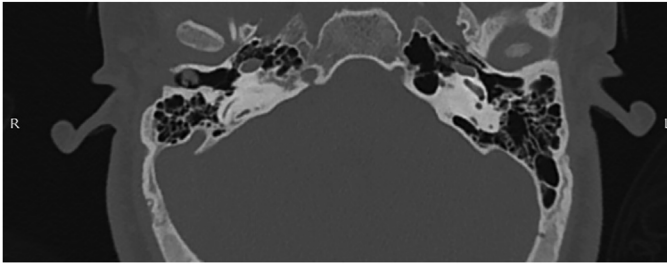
Axial CT scan showing ASEEC Right ear with cerumen (*white arrow*) plug medial to the stenosis.
